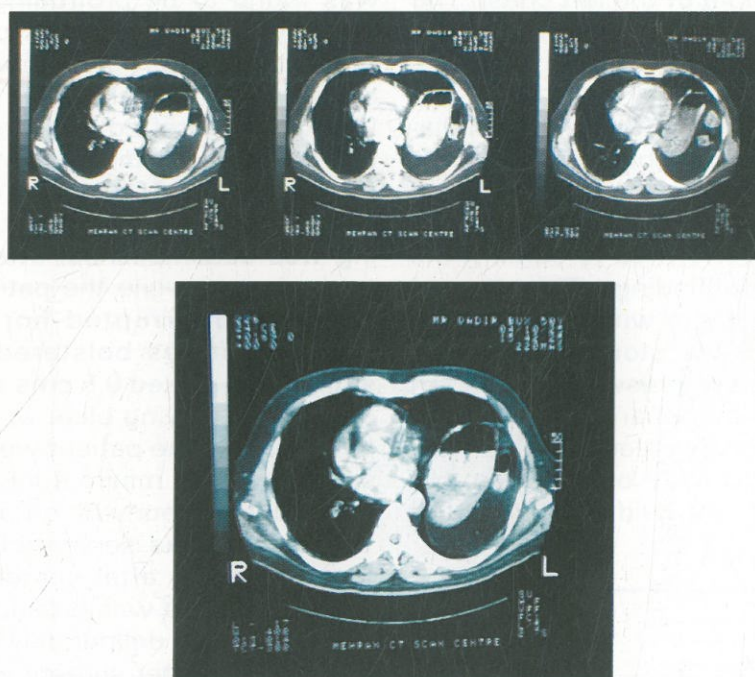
CT scan showing the hernial sac and its contents
